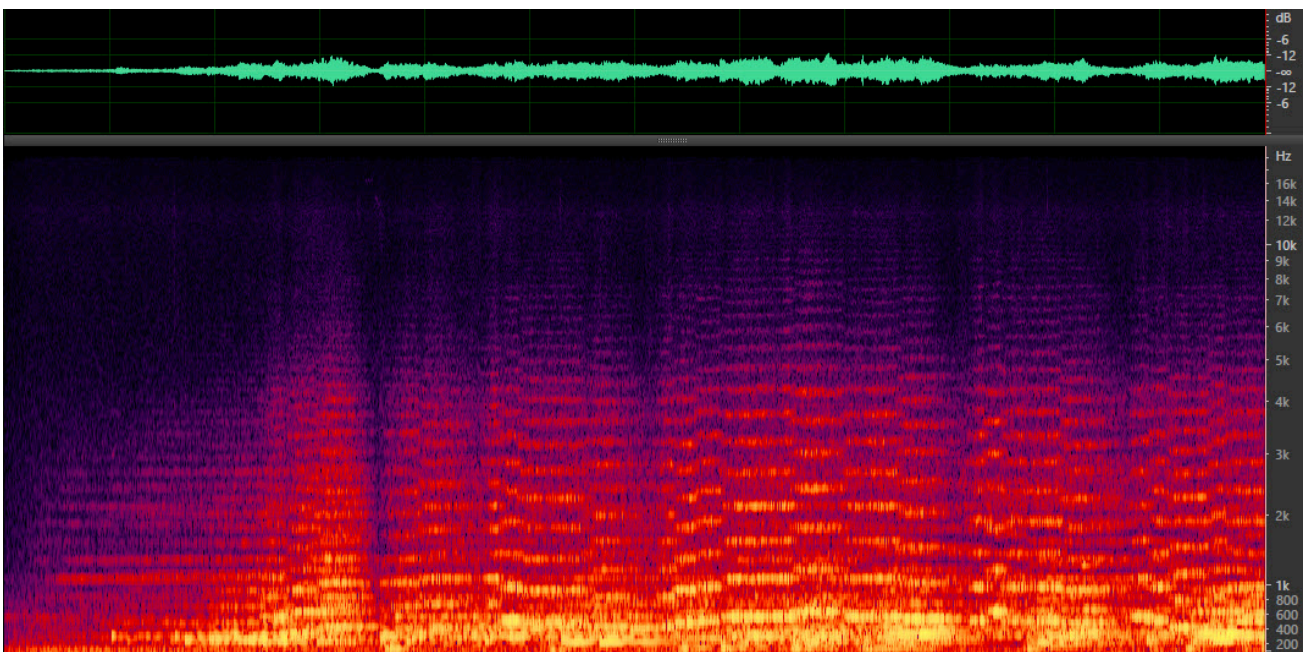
Sonograms and spectrograms of the memory delay music.
